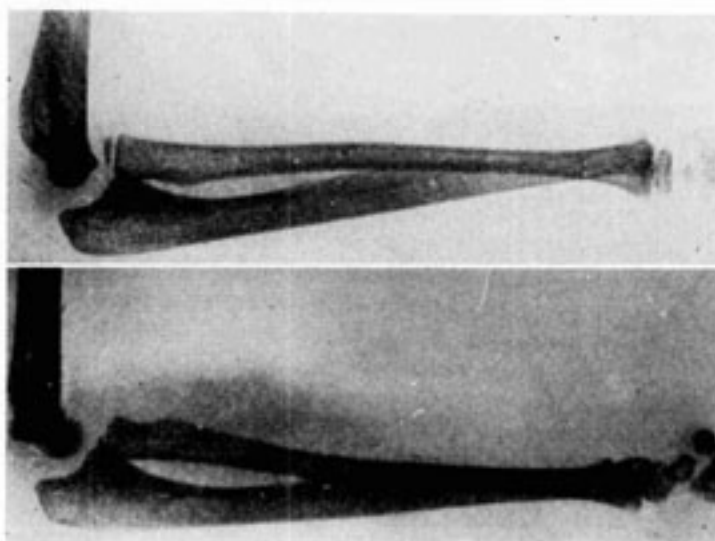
(Top) With pronation the radius "shortens." The wrist conjugal cartilages of the radius and the ulna are at the same level. (Bottom) With supination the radius "lengthens." Looking at a roentgenogram of the wrist, one can know if the radius is in pronation or supination.
